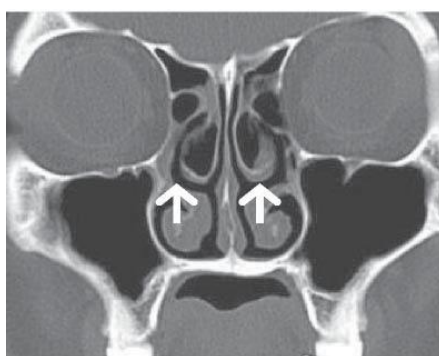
Coronal CT scan shows bilateral anterior ethmoid air cells lying deep to lacrimal bone and bordering floor of frontal sinuses (Aggernasi cell).
